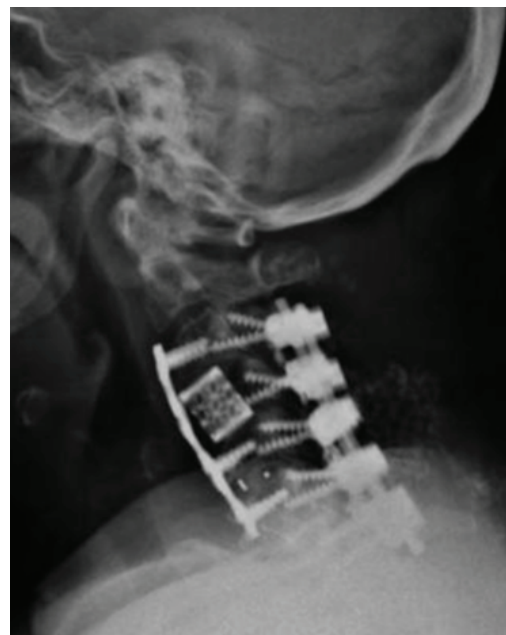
Postoperative lateral cervical X-ray shows anterior C4 corpectomy and C5–C6 discectomy with cage, vertebral substitute, and anterior plate. Posteriorly, laminectomy from C3 to C7 with lateral mass screw fixation is evident. The alignment is satisfactory with stable reconstruction.
